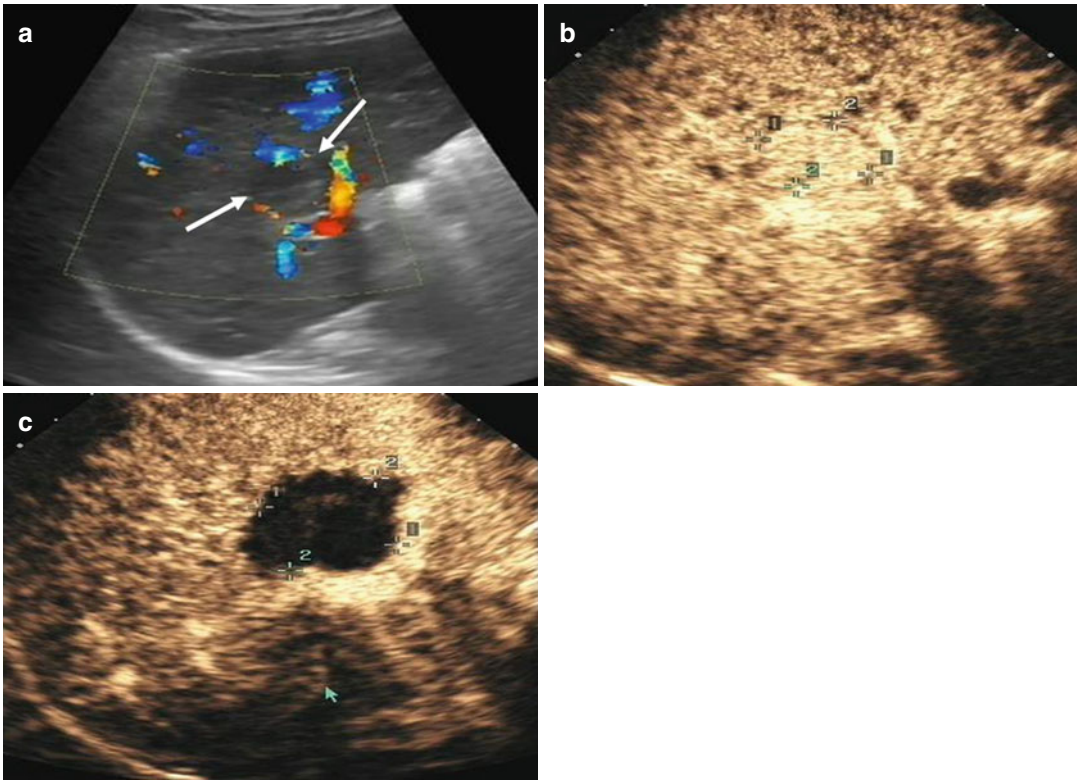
Transverse images in a 41-year-old man with a single focus of HCC (2.5×2.0 cm) and accompanying cirrhosis. (a) Conventional ultrasound before ablation shows a hypoechoic nodule surrounded by several large vessels at liver hilum (arrows). (b) Contrast-enhanced ultrasound
